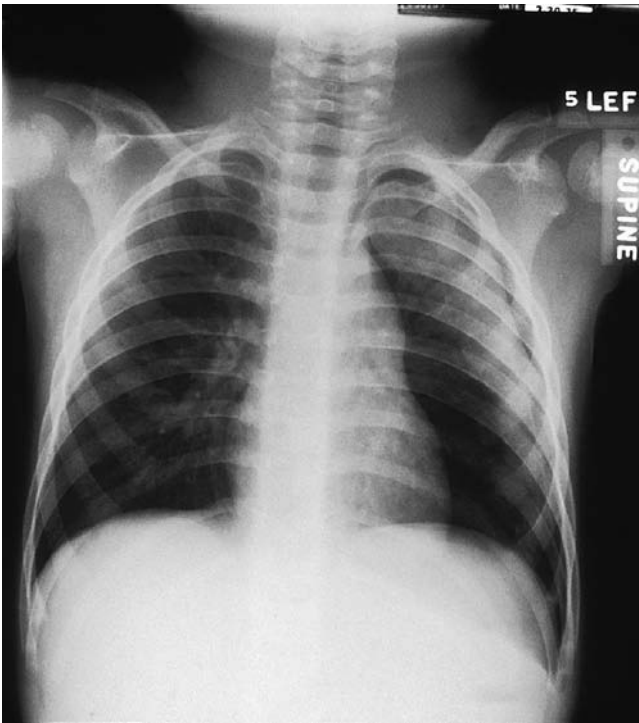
This 3-year-old child was an unrestrained passenger in a motor vehicle accident. The patient was tachypneic and had decreased breath sounds on the left side but was otherwise asymptomatic. Chest radiograph revealed a left pneumothorax with a pulmonary contusion.
